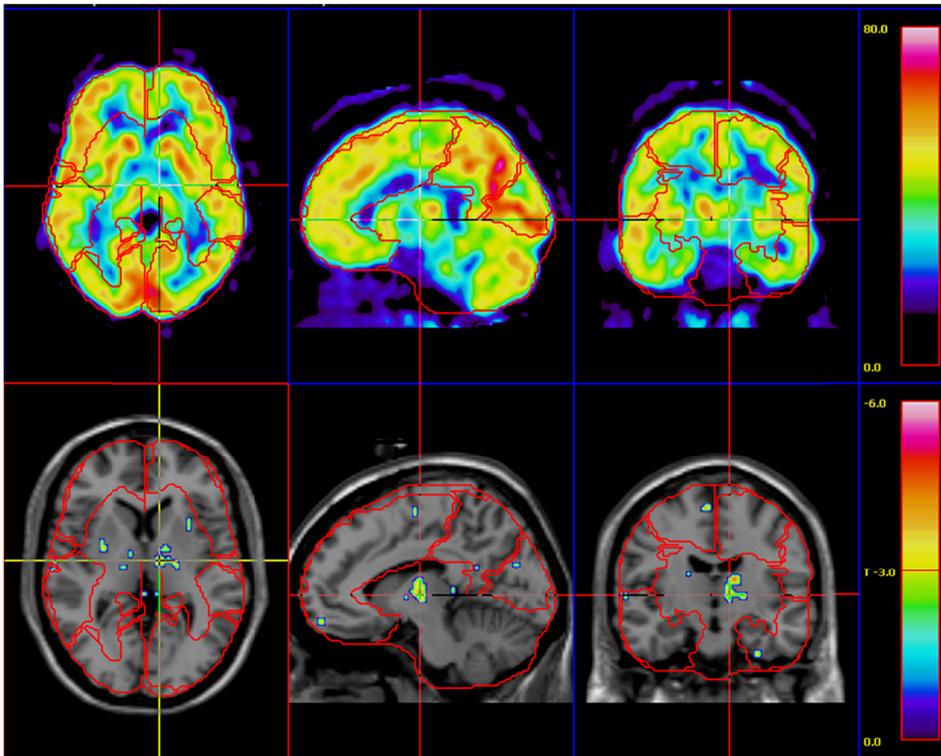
FDG PET in Patient 3. Decreased uptake in the left thalamus
